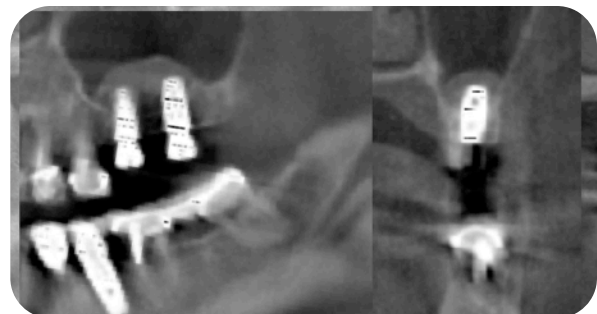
Postoperative radiograph. Note excellent lateral condensation of graft reaching medial and lateral wall of sinus.
